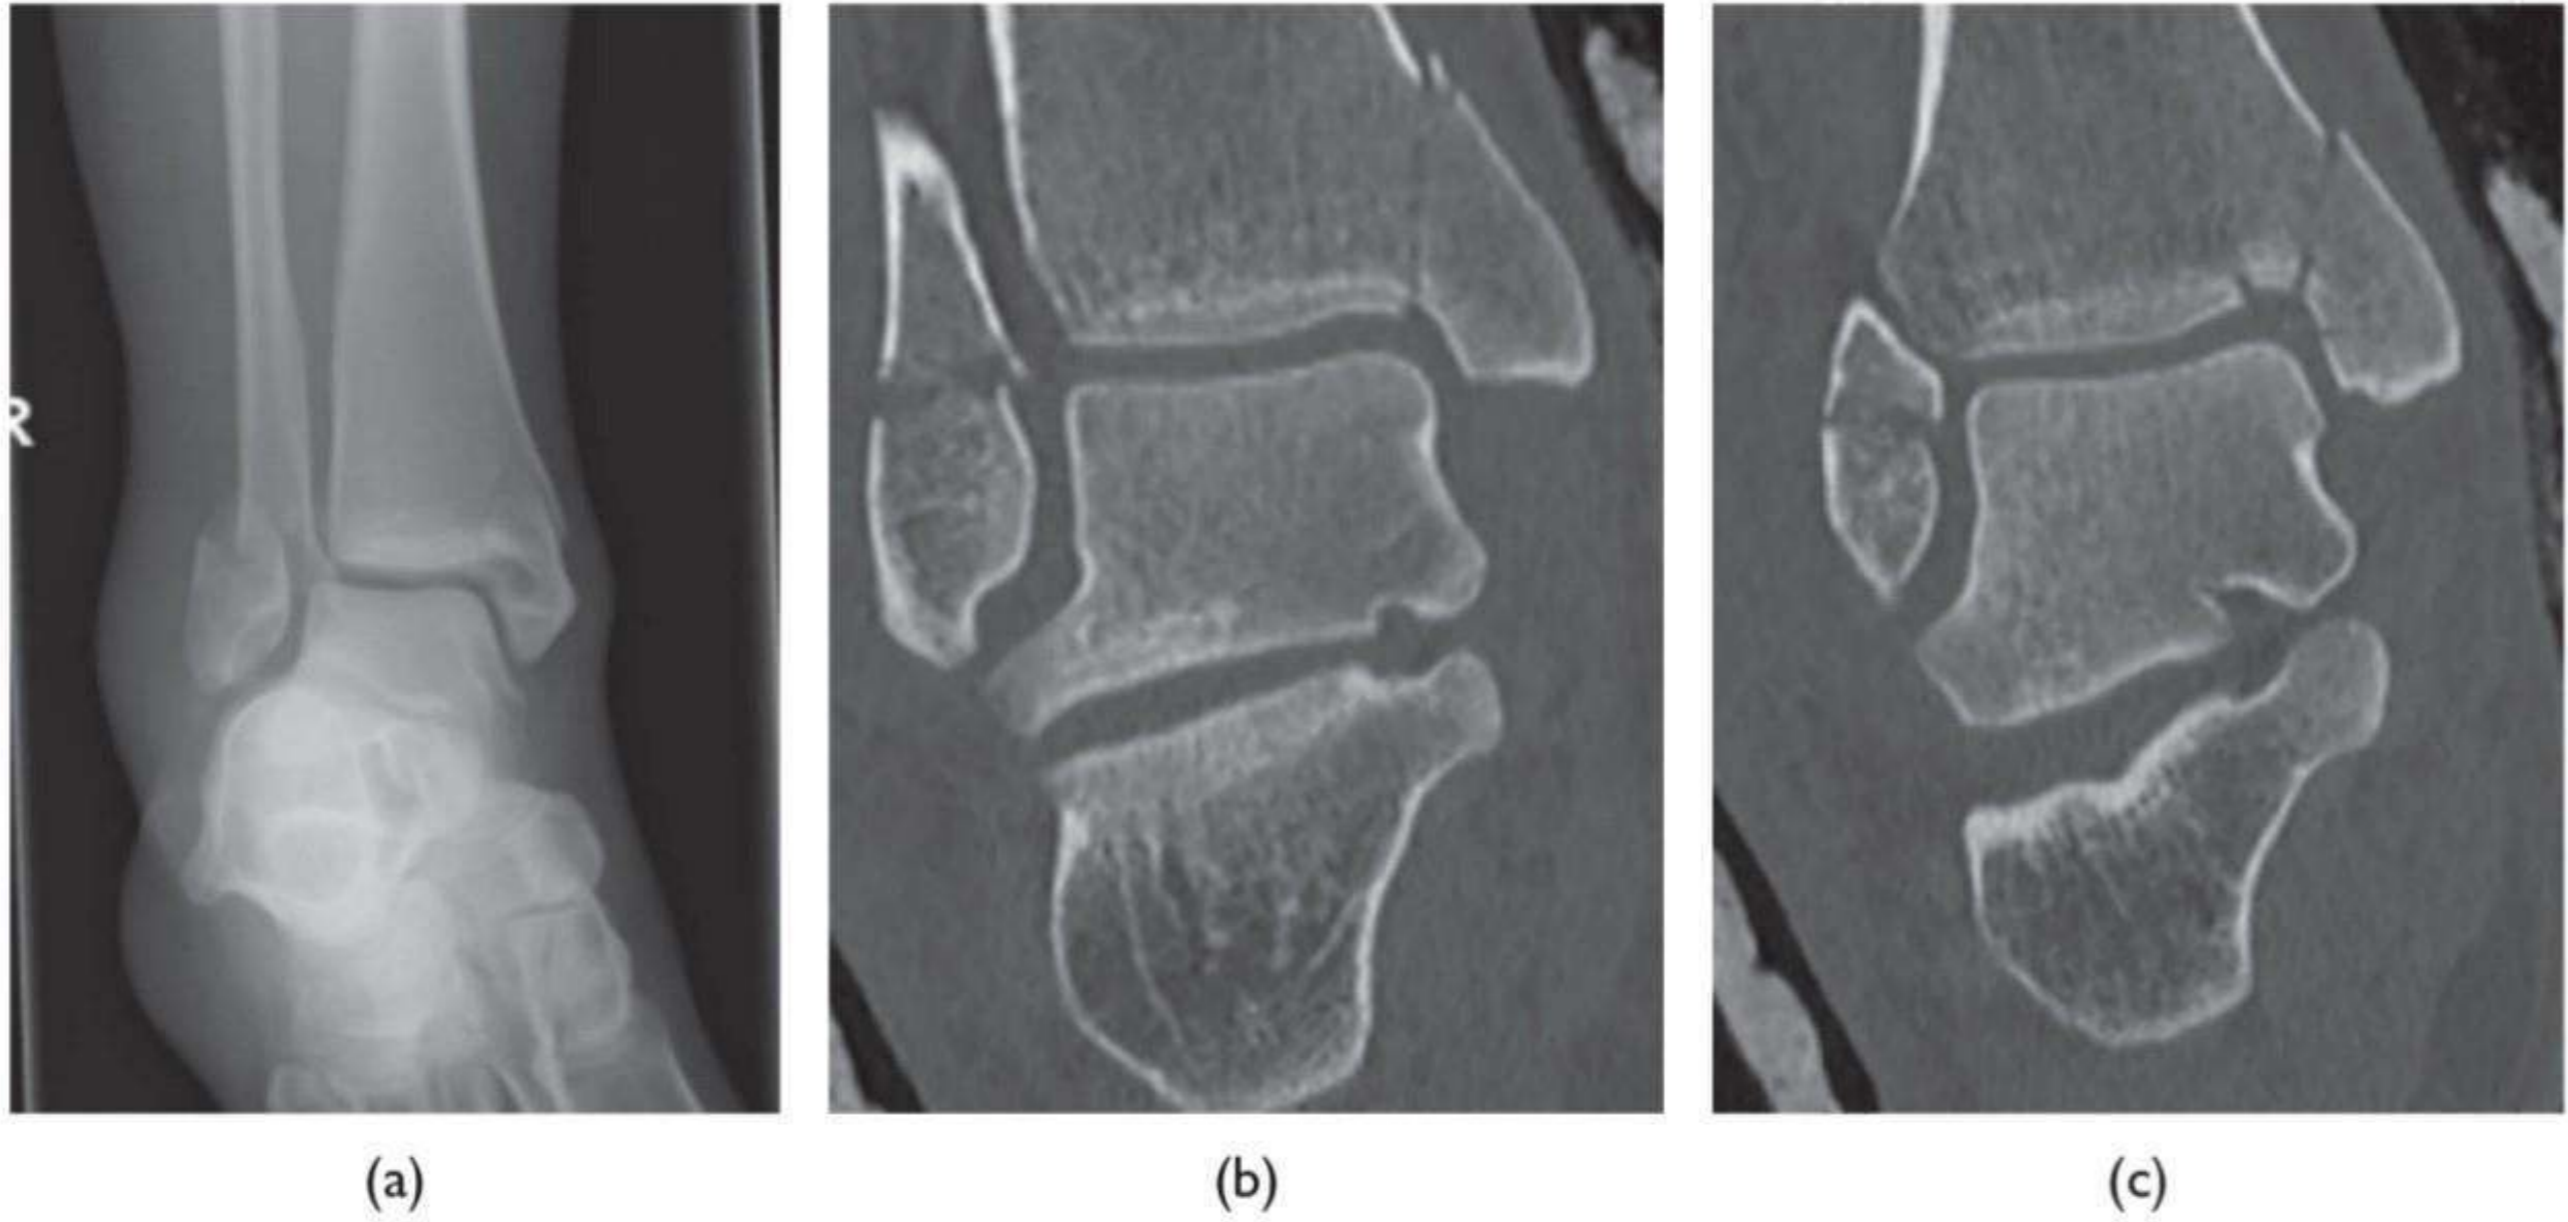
Right ankle (a) radiograph; (b), (c) coronal CT
